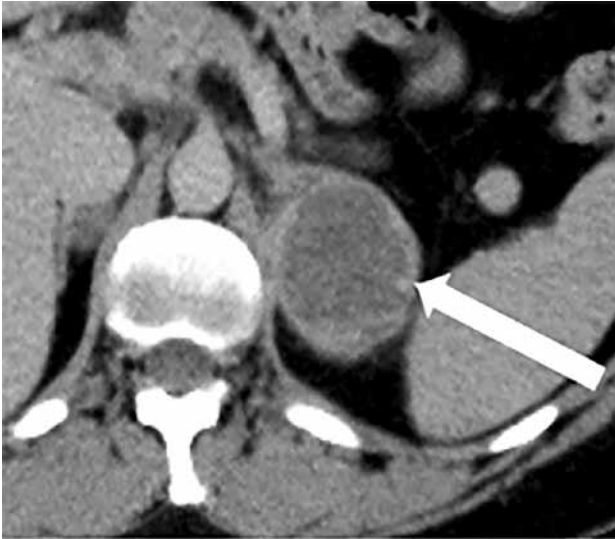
Adrenocortical carcinoma (arrow) presents with a large central non-enhancing hypodense region consistent with necrosis on axial native CT. (Thomas AJ, Habra MA, Bhosale PR, Qayyum AA, Ahmed K, Vicens R, Elsayes KM. Interobserver agreement in distinguishing large adrenal adenomas and adrenocortical carcinomas on computed tomography. *Abdom Radiol* 2018; 43: 3101-3108)
